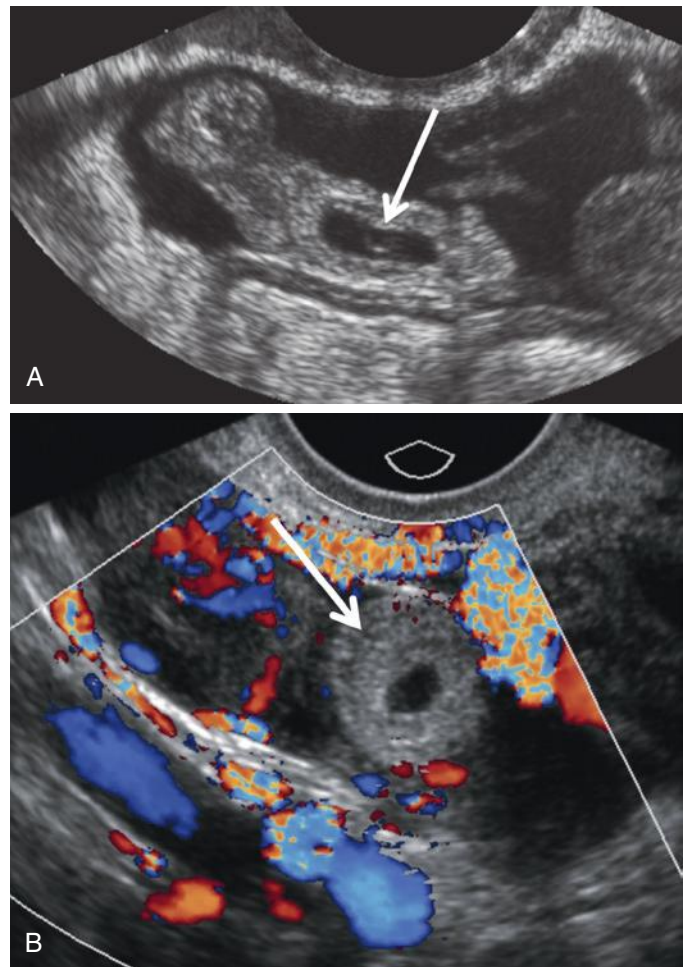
Ectopic pregnancy in the ampullary portion of a fallopian tube. The patient presented with vaginal bleeding and a positive serum human chorionic gonadotropin (hCG). A, Transvaginal longitudinal scan of the ampullary portion of the fallopian tube shows that it is surrounded by free pelvic fluid and contains a gestational sac with a yolk sac (arrow). B, Transverse color Doppler transvaginal sonogram of the hyperechoic tubal ring of the ectopic gestation shows no demonstrable blood flow in the echogenic ring surrounding the gestational sac (arrow).
